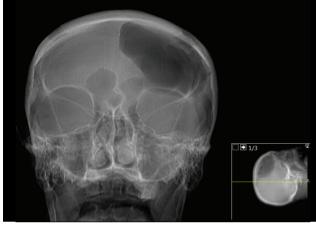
Radiography image of the computerized tomography with the hyper transparence on the left side of frontal image
